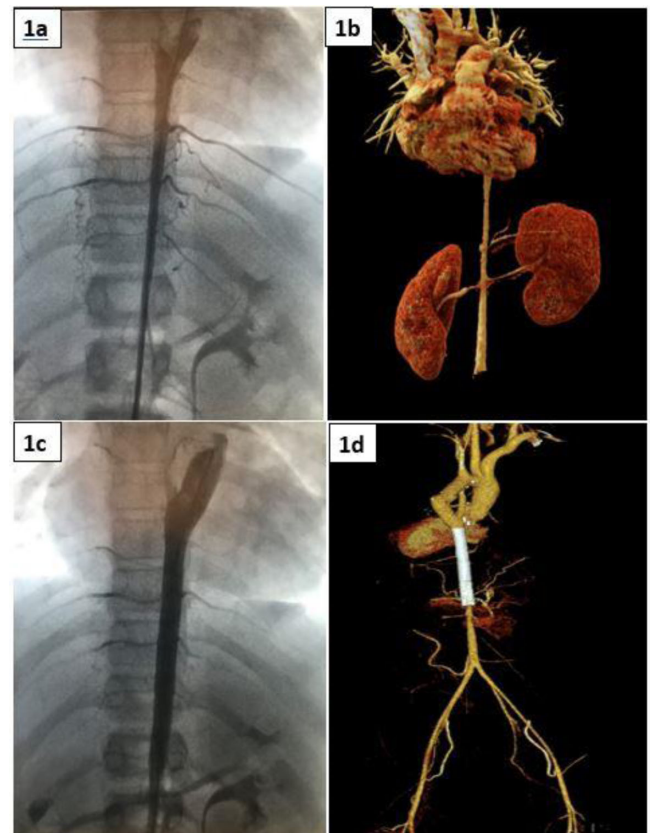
Angiography images before and after stent implantation (Fig1a and 1c). CT angiography images before and after cardiac catheterization (Fig 1b and 1d).
